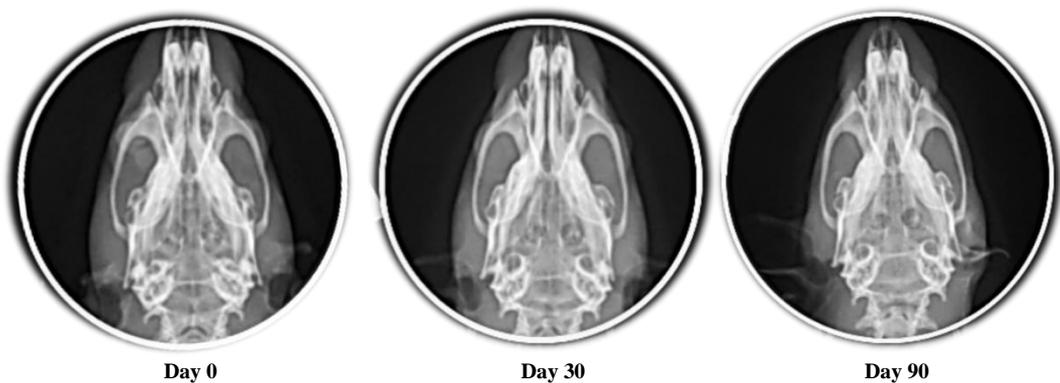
Radiographs of calvarial bones on days 0, 30 and 90.
